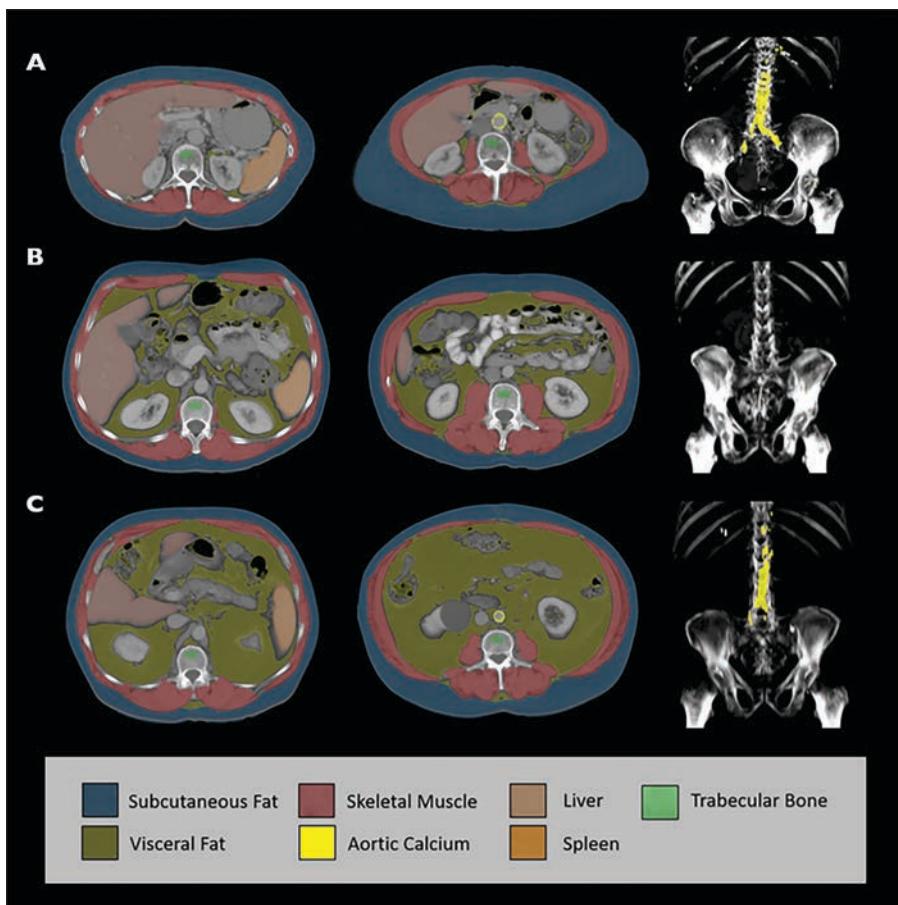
Examples of baseline CT-based body composition assessment in patients with colorectal cancer.
